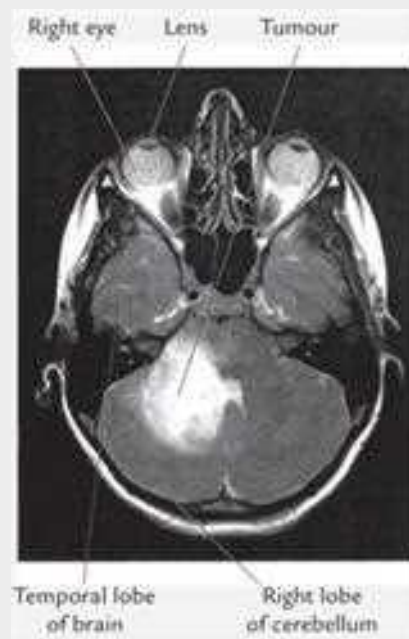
MR image of a right-sided tumour in the cerebellum. Source: *Heylings, David JA, Spence, Roj AJ, Kelly, Barry E. Integrated Anatomy. Oxford: Elsevier Science Ltd, 2007.*
